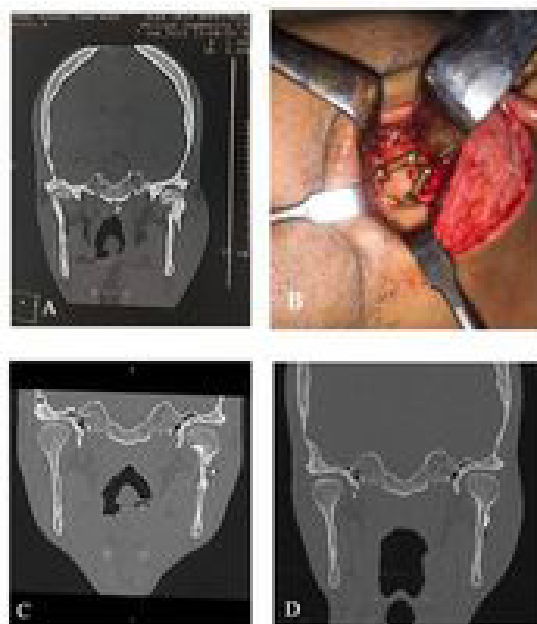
A: Preoperative CT, B: Fixation with trapezoidal 3D plate, C: immediate postoperative CBCT, D: 6 months postoperative CBCT.
